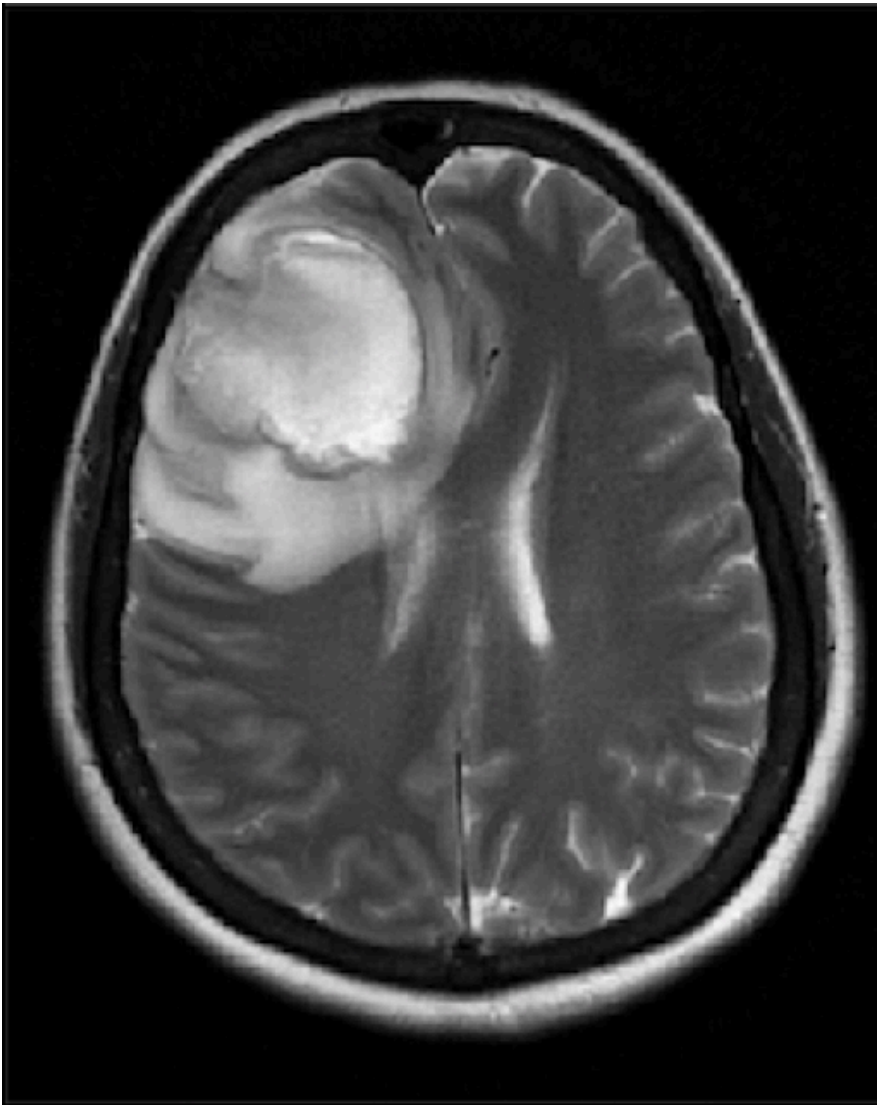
MRI of the head showing a large lesion in the right frontal lobe with corresponding mass effect and subfalcine herniation.
